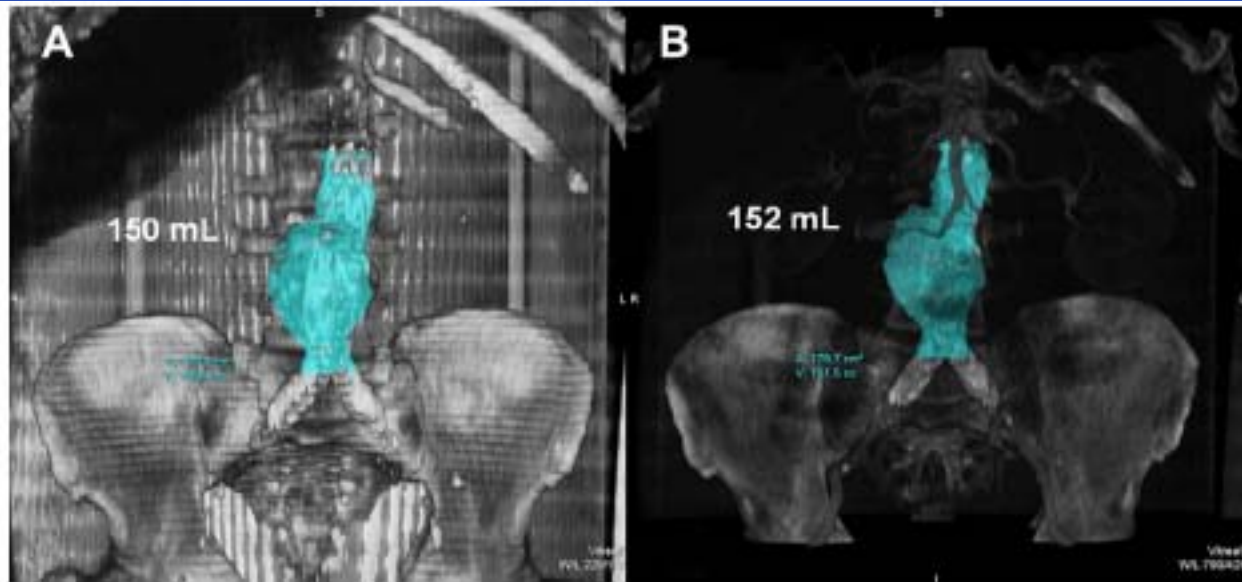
Aortic volumes obtained with noncontrast computed tomography (A) and contrast-enhanced computed tomography (B).
